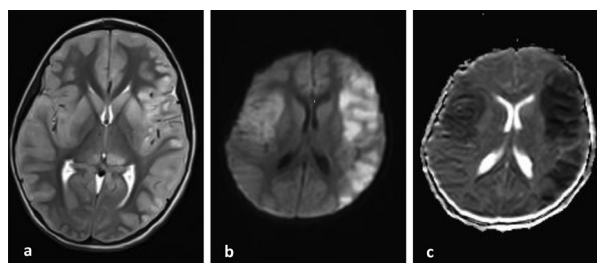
a) MRI T2-weighted image showing bilateral asymmetrical (left more than right) cortical high intensity signal with cortical swelling along with high signal in the ventromedial thalami, b) MRI diffusion weighted image (DWI) and c) apparent diffusion coefficient (ADC) images showing bilateral cortical cytotoxic edema in the form of diffusion restriction and corresponding drop in the ADC values.
